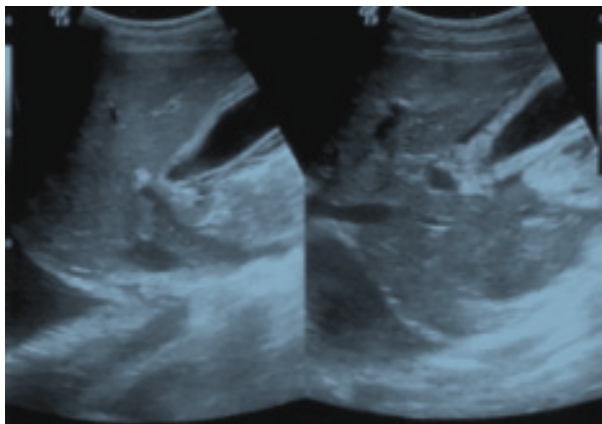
Ultrasound scan shows marked thickening of the gallbladder and pericholecystic fluid in the absence of any stones or sludge
